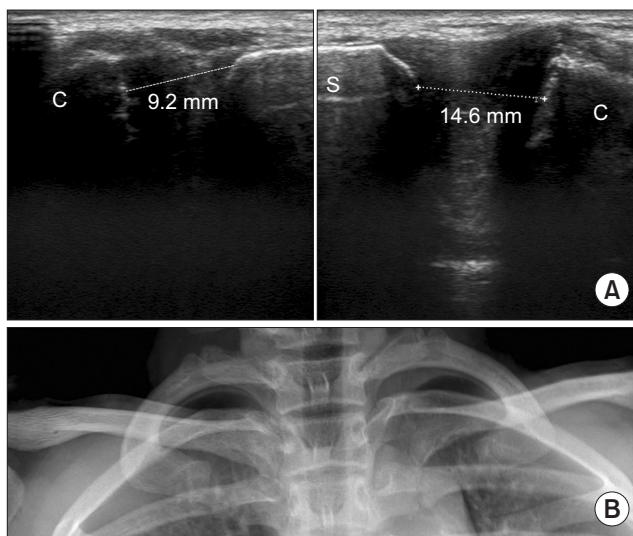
(A) Long axis sonographic image of the medial clavicles demonstrates normally located left medial clavicle. The Sternoclavicular joint gap was 9.2 mm in right, 14.6 mm in left. (B) The radiographic image shows same level of both clavicle in Hobb's view. S: sternum, C: clavicle.
